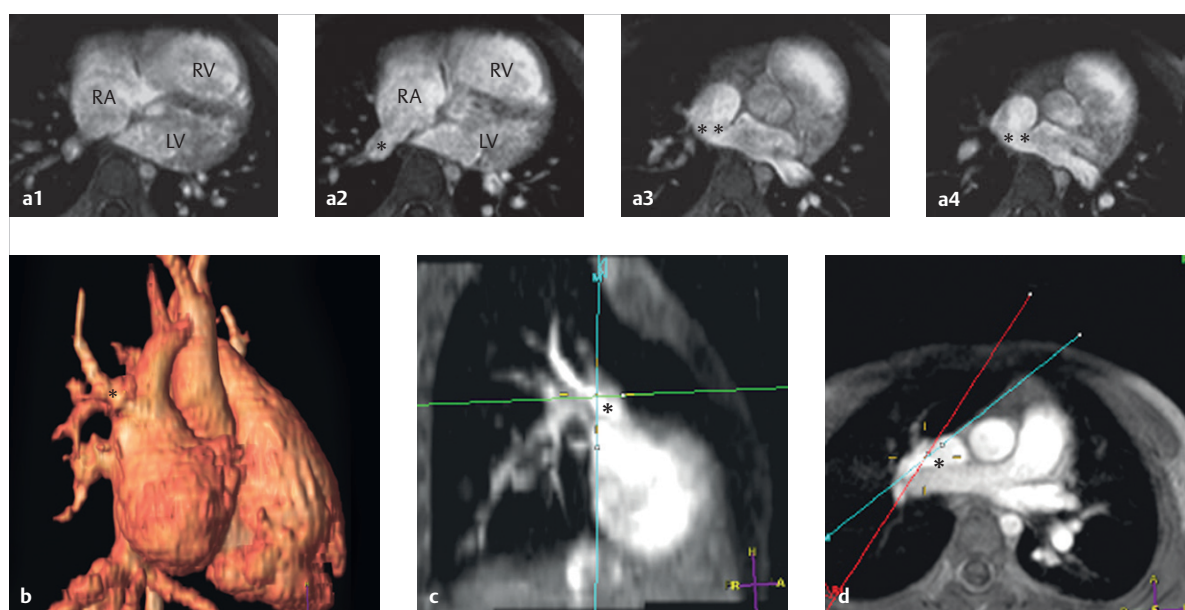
SVD with concurrent PAPVR of a right superior pulmonary vein to the superior vena cava and right atrium. The single asterisk marks the right superior pulmonary vein. The PAPVR is especially easy to visualize using a 3-D whole heart MRI sequence (a). Both in MRI and MDCT (► Fig. 4.5), a 3-D data set offers the opportunity to depict the surface via volume rendering (b), as well as to create precise reconstructions using multiplanar reformats in various orientations (c, d).
